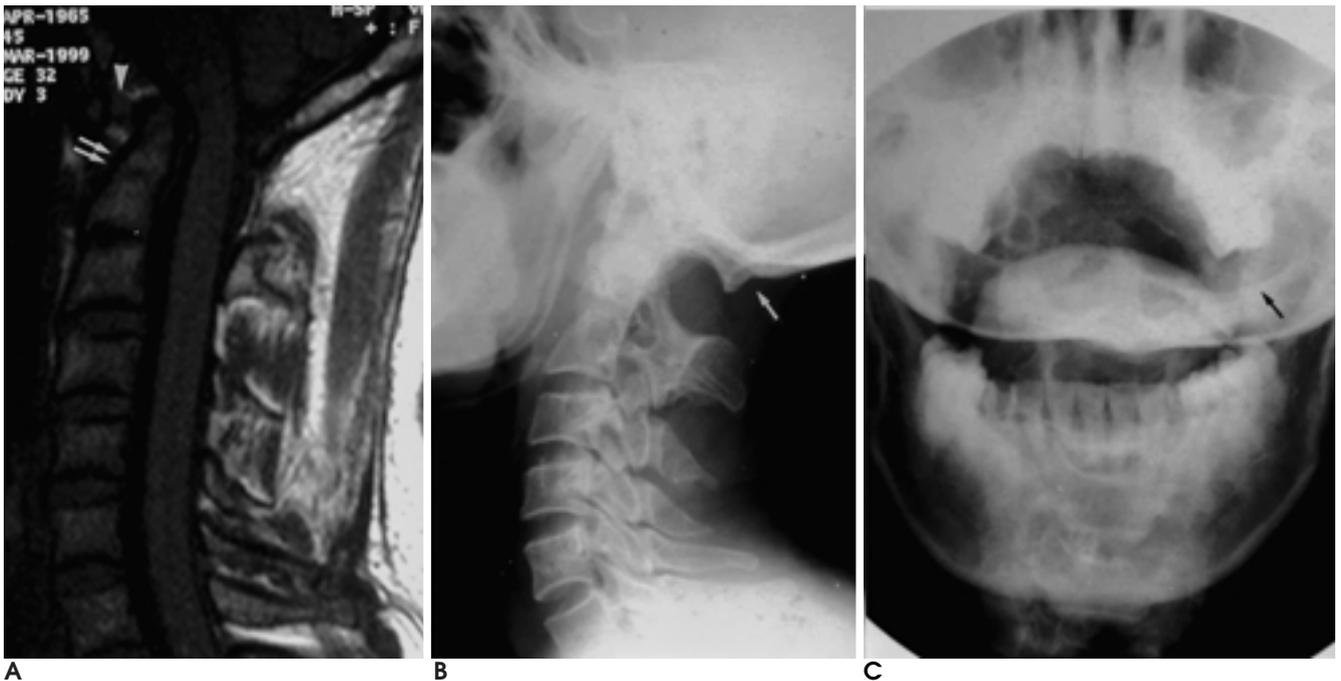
"Atlanto-occipital assimilation" in a 34-year-old woman. Sagittal T1 weighted image (A), lateral radiograph of the cervical spine (B) and open-mouth radiograph (C) show the fusion of the atlas to the skull base (arrow), incomplete block vertebrae of second and third cervical vertebrae (double arrow) and atlantoaxial subluxation (arrow head).
